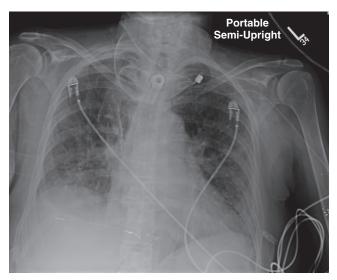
Residual glue on a computed radiography imaging plate resulted in this artifact, causing the plate to be removed from service. (Courtesy David Clayton, M.D. Anderson Cancer Center.)
